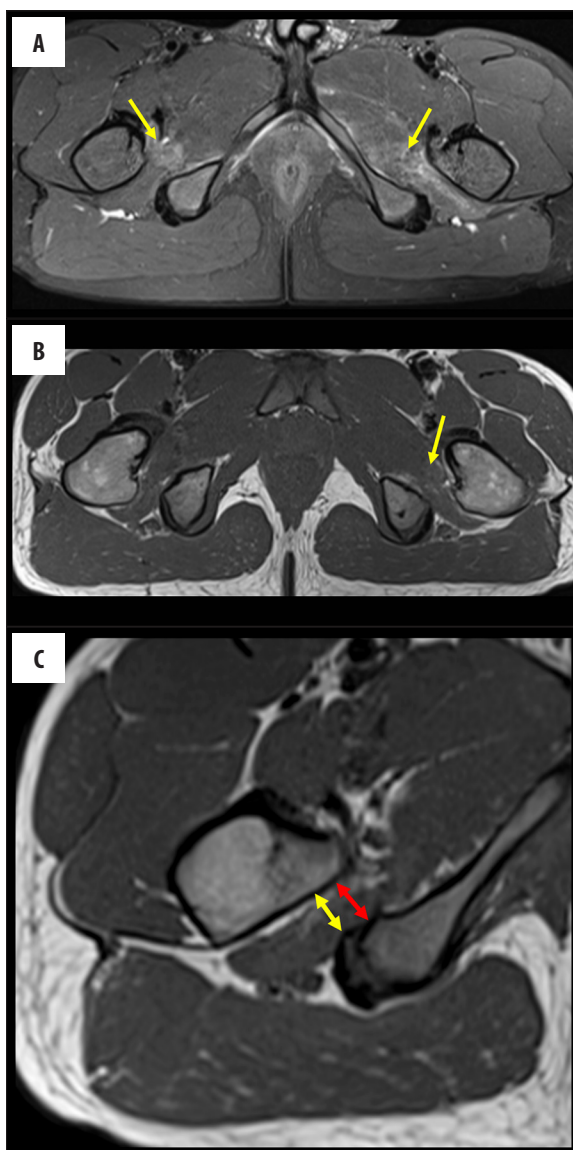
MRI of the hips. PD-weighted images with fat suppression in the axial plane (A) show bilateral edema of the quadriceps femoris muscles (arrows), the abnormality is more prominent on the left. On T1-weighted axial images (B), there is a subtle fatty atrophy of the quadriceps femoris muscles (arrow). (C) A T1-weighted image in the axial plane showing the technique of IFS measurement (red) and QFS (yellow), as described by Torriani et al. [1]. Both IFS and QFS are markedly reduced.
